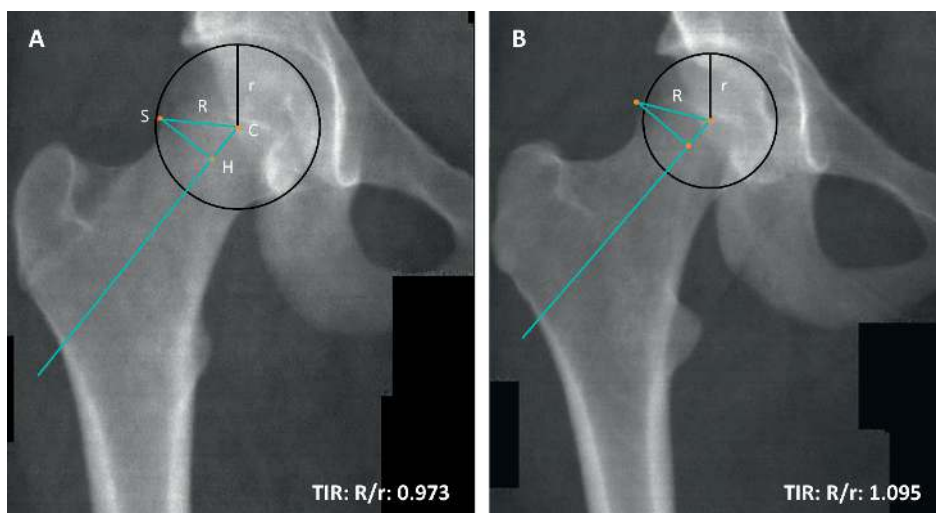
Measurement of the triangular index ratio (TIR) on a dual-energy x-ray absorptiometry (DXA) image of the right hip. (A). The center of the femoral head (point C) and the radius are determined by the best-fitting circle around the femoral head. From the midpoint of the radius (point H), a perpendicular line is generated to the superolateral cortex of the femoral head-neck junction (point S). The TIR of 0.973 in this sample is the ratio of the length of R from point S to point C and the length of r, the radius of the best-fitting circle, and represents a spherical femoral head. (B). A right hip with a TIR of 1.095, which represents a primary cam morphology.
